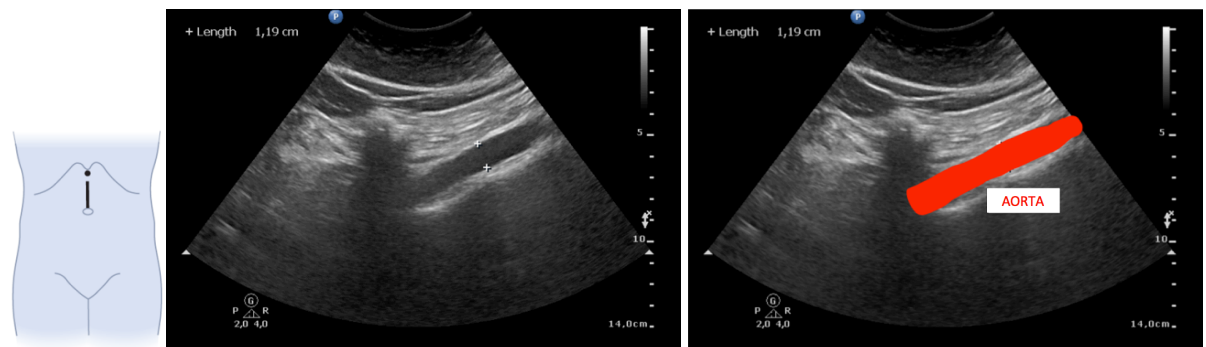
Ultrasonographic image of the abdominal aorta.
